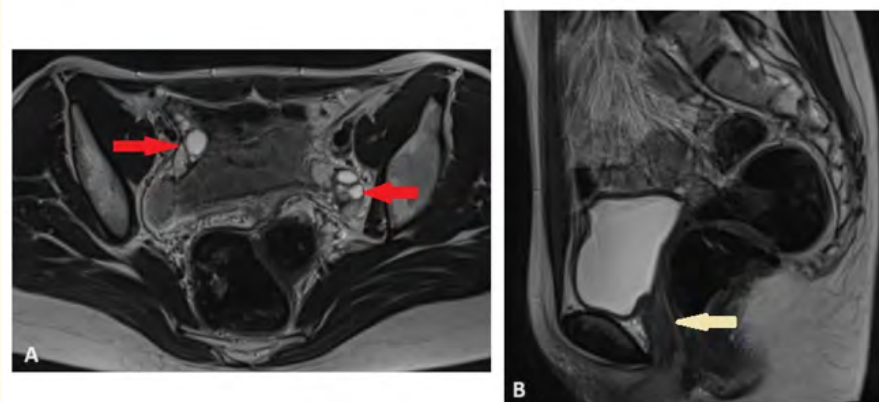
(A, B) axial and sagittal MRI in T2-weighted sequence showing agenesis of the uterus and vagina (yellow arrow) with both ovaries have normal signal and morphology (Red arrows).
